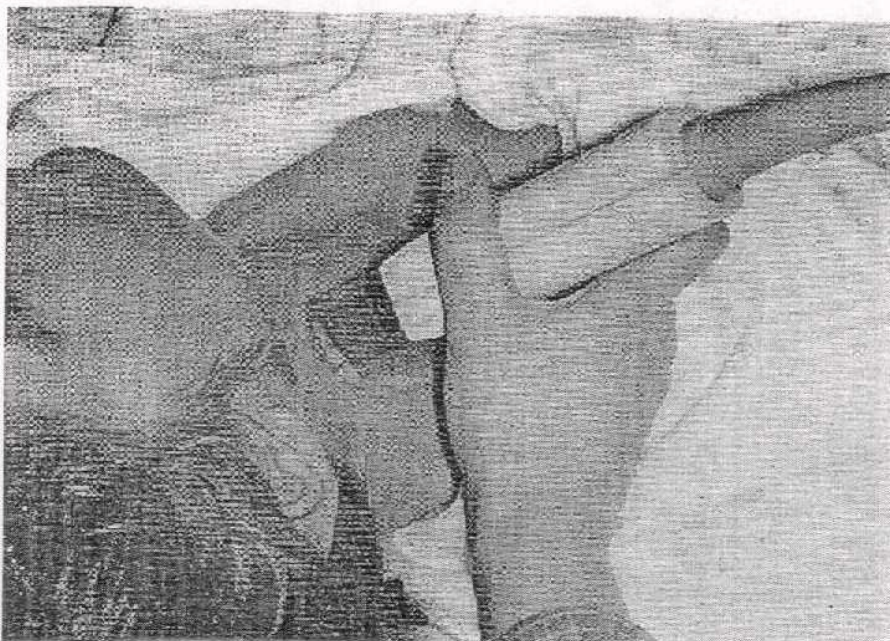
Transducer positioning for longitudinal duplex scanning of carotid arteries in the posterolateral imaging (*Quoted from Diagnostic Ultrasound, 1998*).
